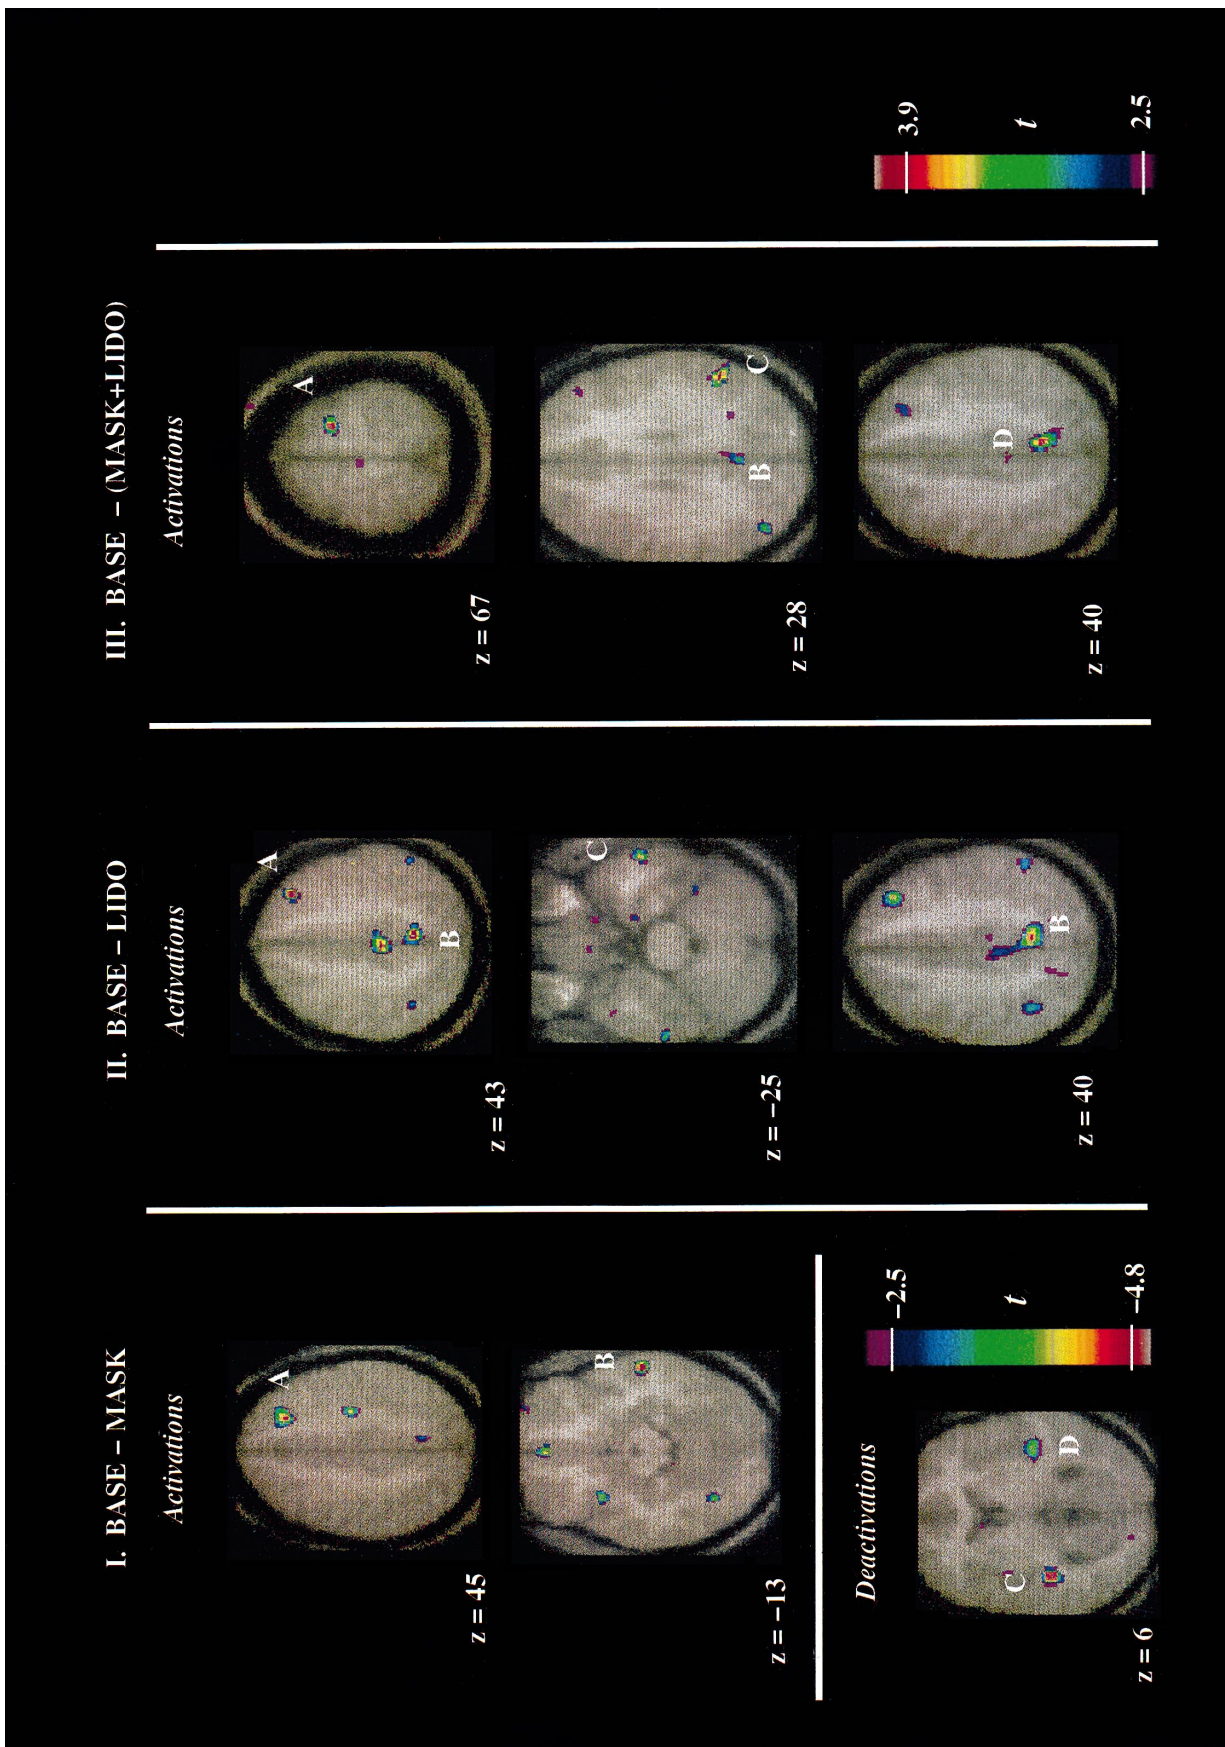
PET maps of brain activity associated with the perception of tinnitus. (I) Activated sites (t -statistic maps) in subtraction base–mask. Foci of increased activity in (A) the right middle frontal gyrus, (B) the right middle temporal gyrus and decreases of activity in (C) the left transverse temporal and (D) the right superior temporal gyri. (II) Selected t -statistic maps from subtraction base–lido. Foci of increased activity in (A) the right middle frontal gyrus, (B) the right precuneus and (C) the right middle temporal gyrus. (III) Selected t -statistic maps of activation sites in subtraction base–masklido. This combined suppression by masking sound and intravenous lidocaine contrasted to baseline (base–masklido) elicited foci of activation in (A) the right superior temporal gyrus, (B) the right posterior cingulate gyrus, (C) the right inferior parietal lobule and (D) the right precuneus. The t -maps are shown superimposed on trans-axial slices of average MR images of 12 subjects. Talairach coordinates and t -peak values of the activated sites are listed in Tables 3–5. For further details, see text.
